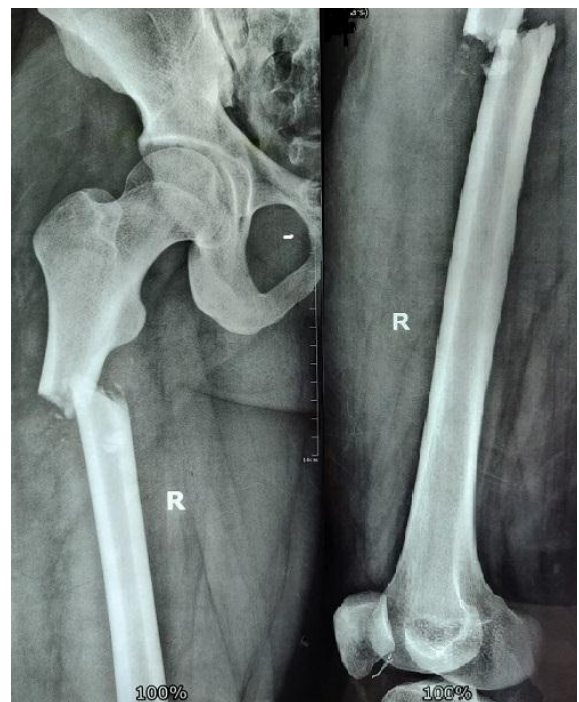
Preoperative X-ray
